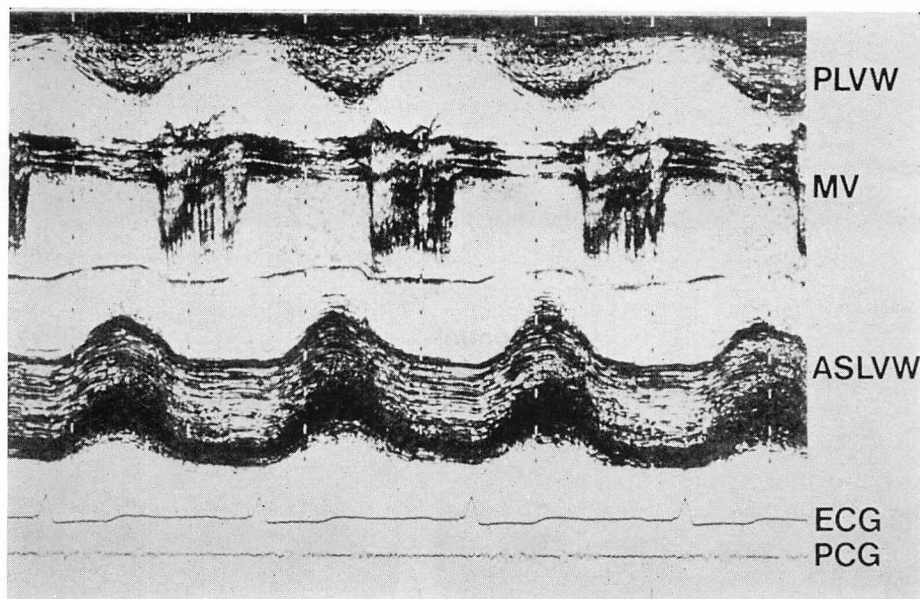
An example of the transesophageal echocardiogram (TEE) of the left ventricle in a case with aortic regurgitation.
